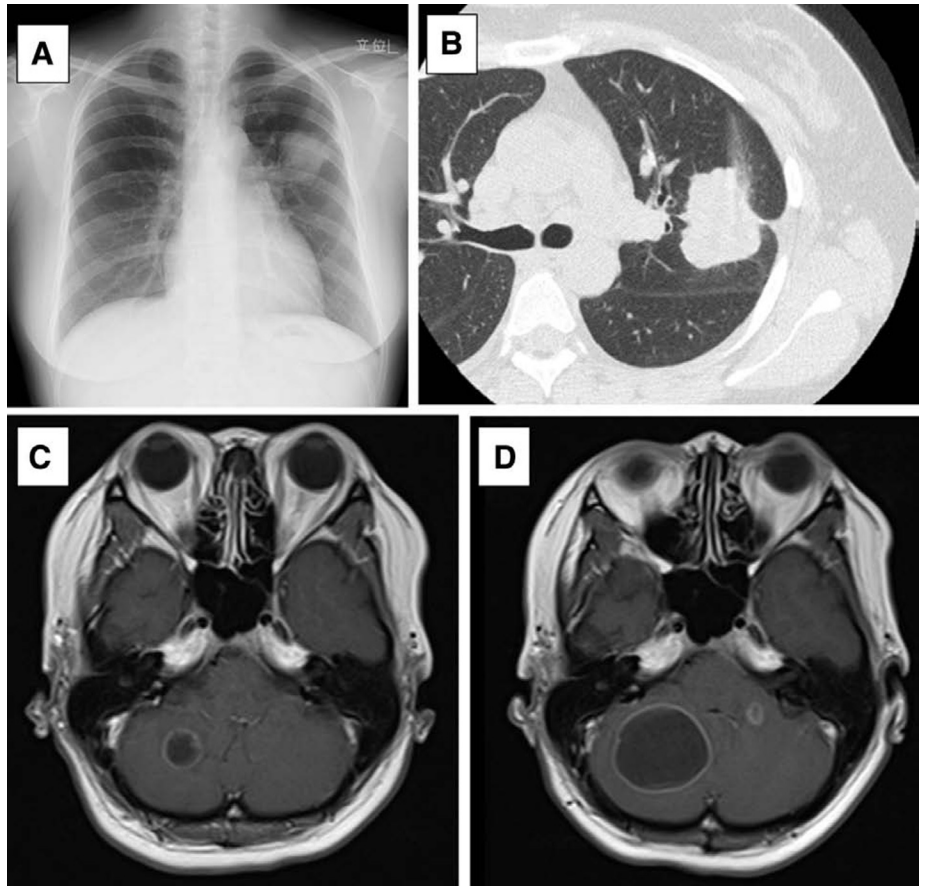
Imaging findings. *A*, Chest radiograph on admission showing a mass in the left upper field; *B*, chest computed tomography scan on admission showing a lung mass in the left upper lobe; *C*, enhanced brain MRI scan on admission showing metastasis to the right cerebellar region; *D*, subsequent enhanced brain MRI revealing an increase in the size of the right cerebellar lesion. MRI, magnetic resonance imaging.
